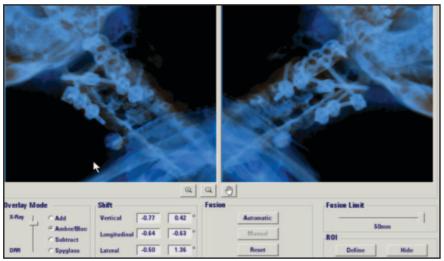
ExacTrac fusion of stereotactic x-rays to DRRs is featured.
